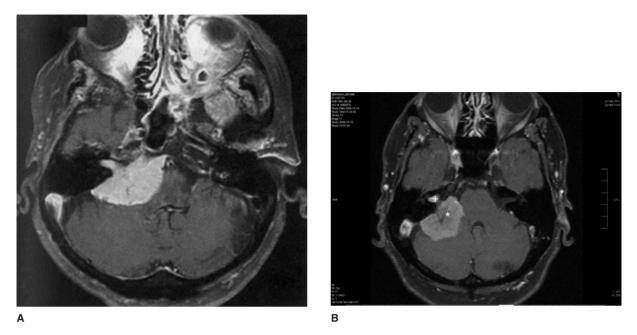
(A) Meningioma of the cerebellopontine angle. A T1-weighted, gadolinium-enhanced MRI scan demonstrates a meningioma of the right cerebellopontine angle. The enhancing lesion has a broad dural base and does not expand the internal auditory canal. (B) Vestibular schwannoma of the internal auditory canal (IAC) and meningioma of the jugular foramen. A T1-weighted, gadolinium-enhanced MRI scan demonstrating an unusual case of small vestibular schwannoma involving the medial IAC (+) and a meningioma involving the lateral IAC, cerebellopontine angle, and jugular foramen (*).
